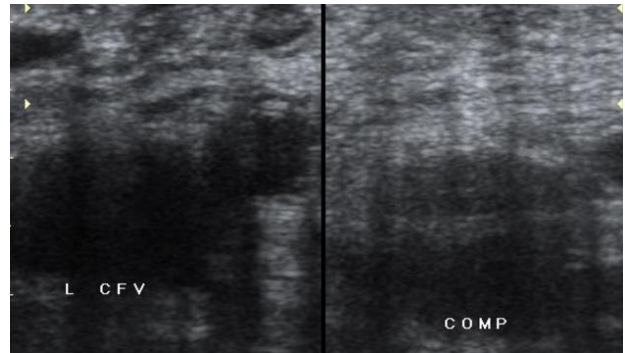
Normal venous doppler scan.
